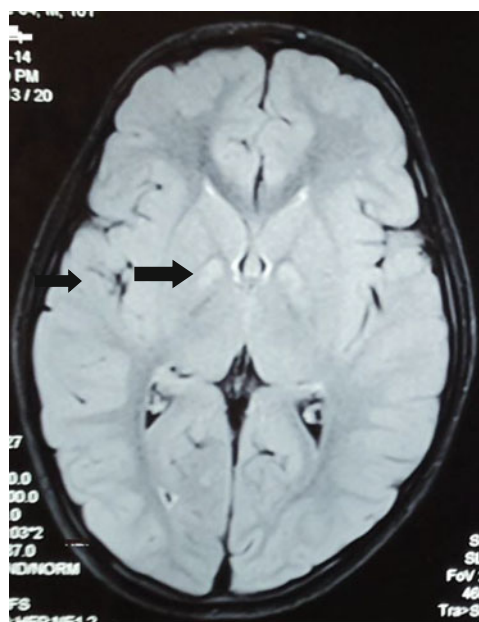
Magnetic resonance imaging of the brain. Axial MRI FLAIR sequence with hyperintensities of globus pallidi (arrowhead)
